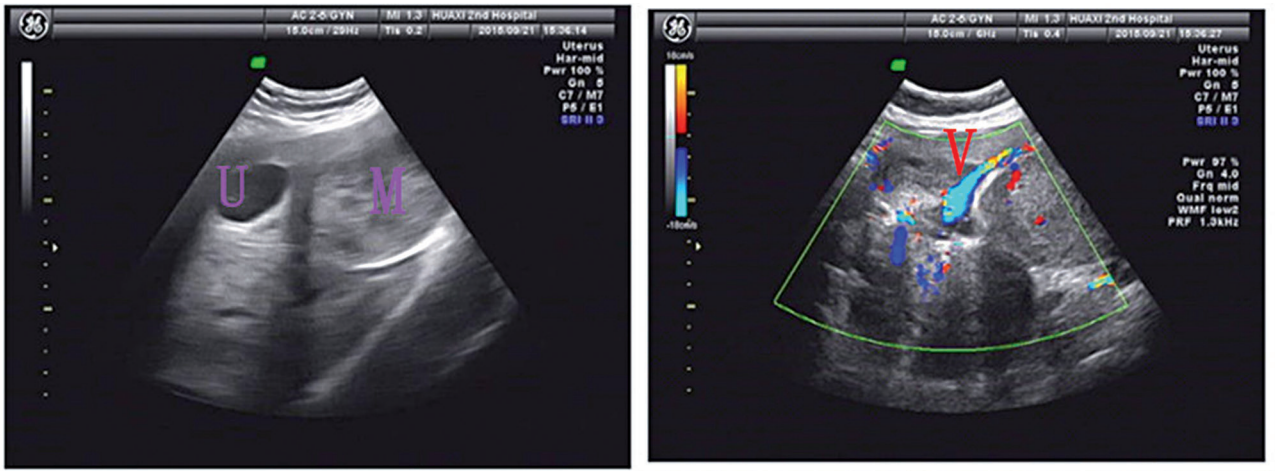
Transvaginal ultrasonography and Doppler findings (U: uterus, M: mass, and V: vascularity).
